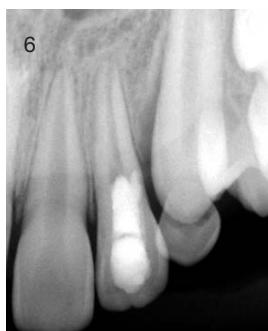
Pre-operative radiograph showing patent canal and evidence of perforation
